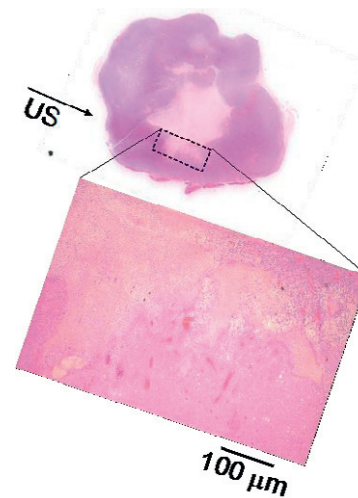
Cross section of tumor tissue exposed to 1 MHz ultrasound in the presence of PCND and phase change ultrasound
